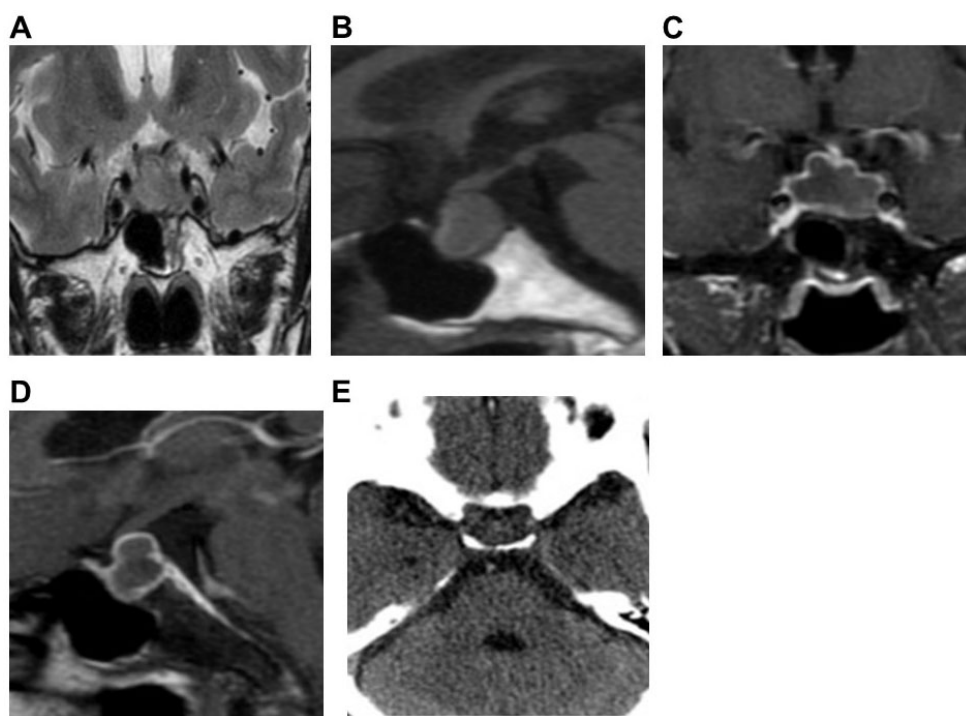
Preoperative pituitary MRI and postoperative CT of Case 1. Preoperative coronal (A) and sagittal (B) MRI scans showed cystic lesions in the sellar. Both T1WI and T2WI were isointensity. There were sellar bone resorption and thickening of nasal septum mucosa. Preoperative coronal (C) and sagittal (D) enhanced MRI scan showed ring enhancement of the cyst wall, thickening and enhancement of the pituitary stalk, enhancement of the dura mater on both sides of the temporal lobe and petroclival region. Postoperative CT (E) showed no recurrence of the pituitary abscess.
